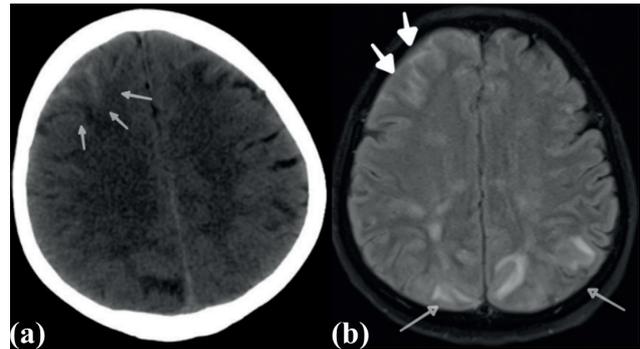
(a) CT scan shows hyperdensity in the right frontal sulci represents hemorrhage (white arrows) (b) Axial FLAIR image of the same patient shows hemorrhage (thick white arrows) and confluent bilateral parietal edema (thin white arrows)
